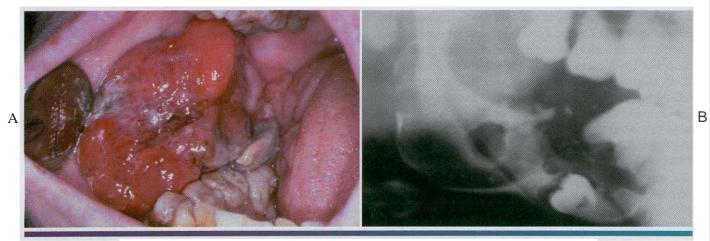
• Ameloblastic fibrosarcoma. A. A Zt-yeer-old woman complained of facial asymmetry and recent increase in size of a mandibular mass that had been present for some years B. Radiograph of the same patient. Note the lytic destruction of the posterior mandible. (Courtesy of Dr. Sam McKenna.)
